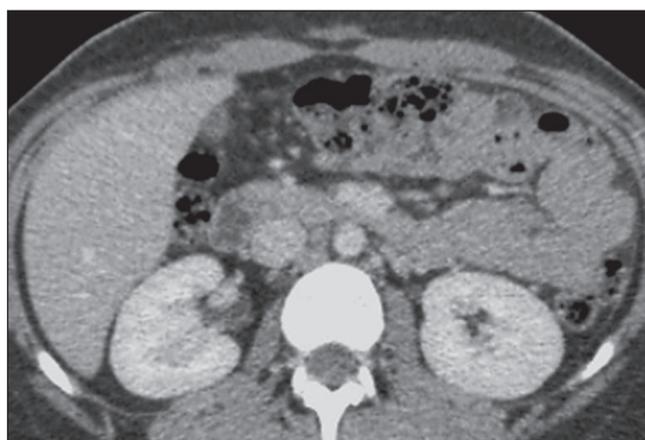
Contrast-enhanced axial CT image of the abdomen after TB treatment, patient 2. Both ascites and peritoneal thickening are now cleared.
